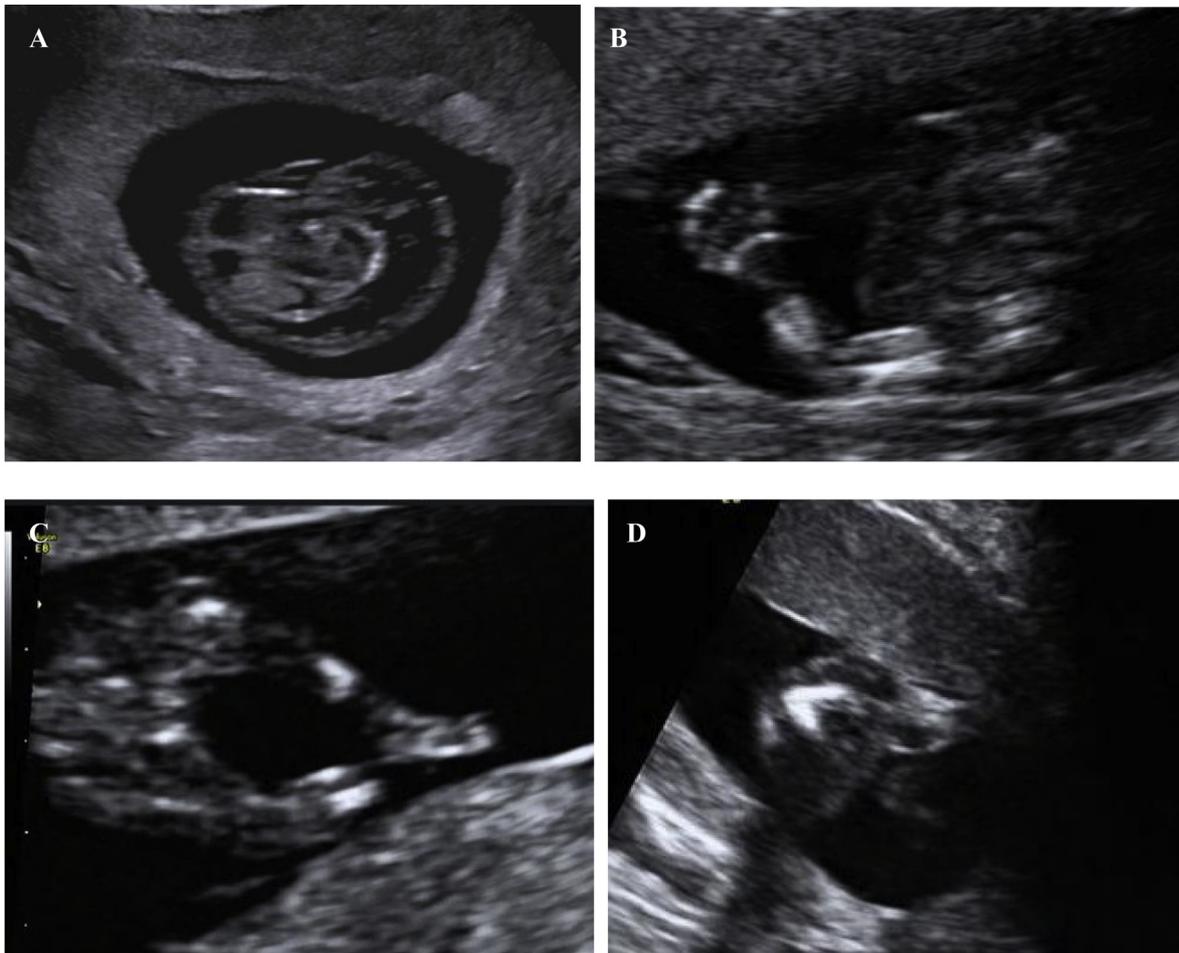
The prenatal ultrasound and genomic sequencing data of the fetus. (A) Cystic hygroma at 12 weeks; (B) Normal left upper limb at 12 weeks; (C) Short and bowed lower long bones at 12 weeks; (D) Angulated femur at 17 weeks; (E) Sanger sequencing shows a de novo c.1005G > A variant in SOX9.
